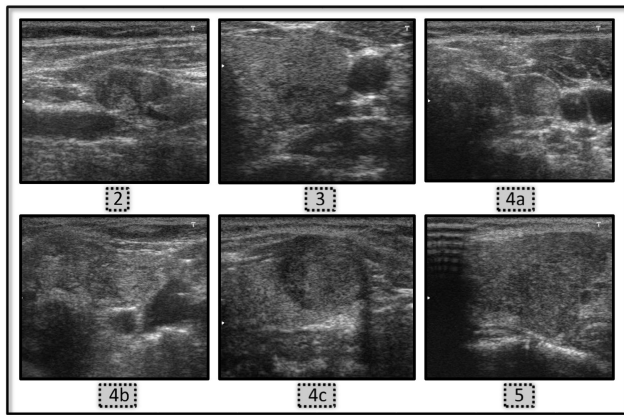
Visual Representation of TI-RADS Classification for Ultrasound Images in the Dataset.
